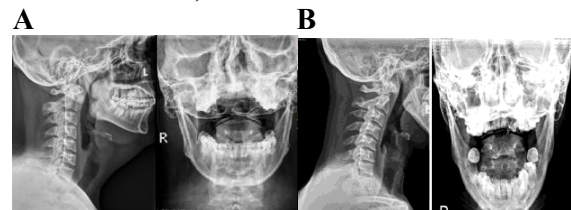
Cervical radiographs 3-month follow up (lateral and odontoid view)
